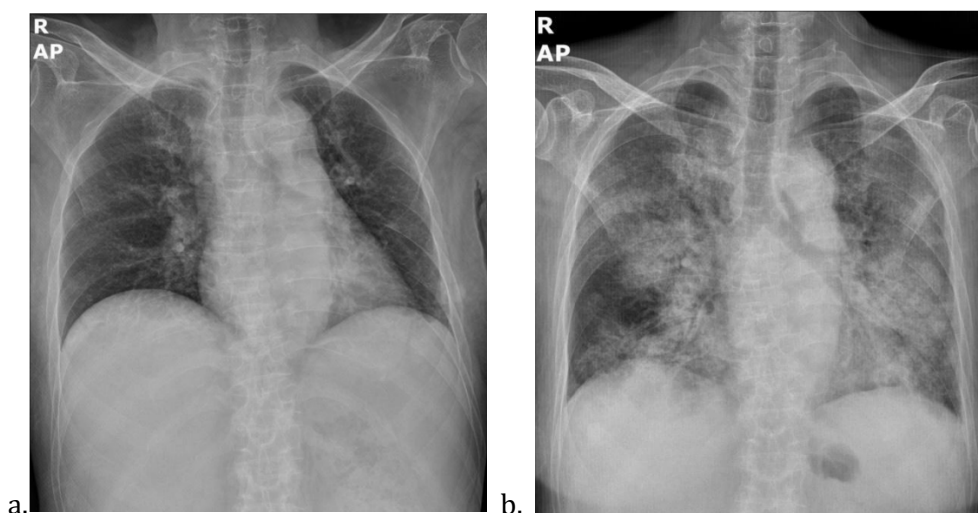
a. Chest X-ray of first-day hospitalization; b. Chest X-ray 6th day of hospitalization
